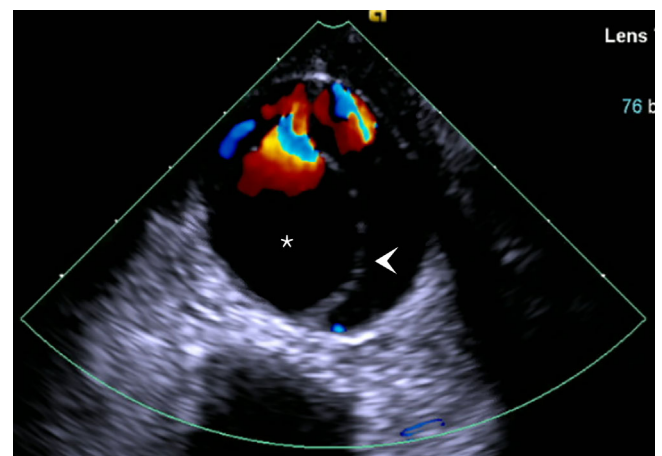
Transesophageal echocardiography with color Doppler identifying true lumen (star) of an aortic dissection (arrowhead), descending aorta short axis view
